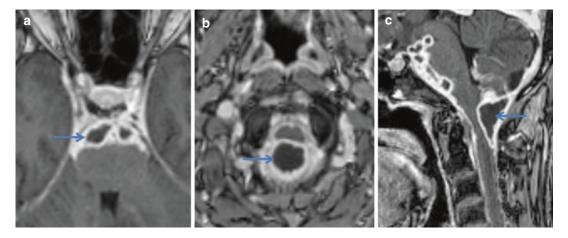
A 50-year-old man presented with TBM with multiple CN involvement while on treatment. Axial post-contrast T1-weighted fat-suppressed images at the level of upper pons (a), medulla (b), and midsagittal section at
